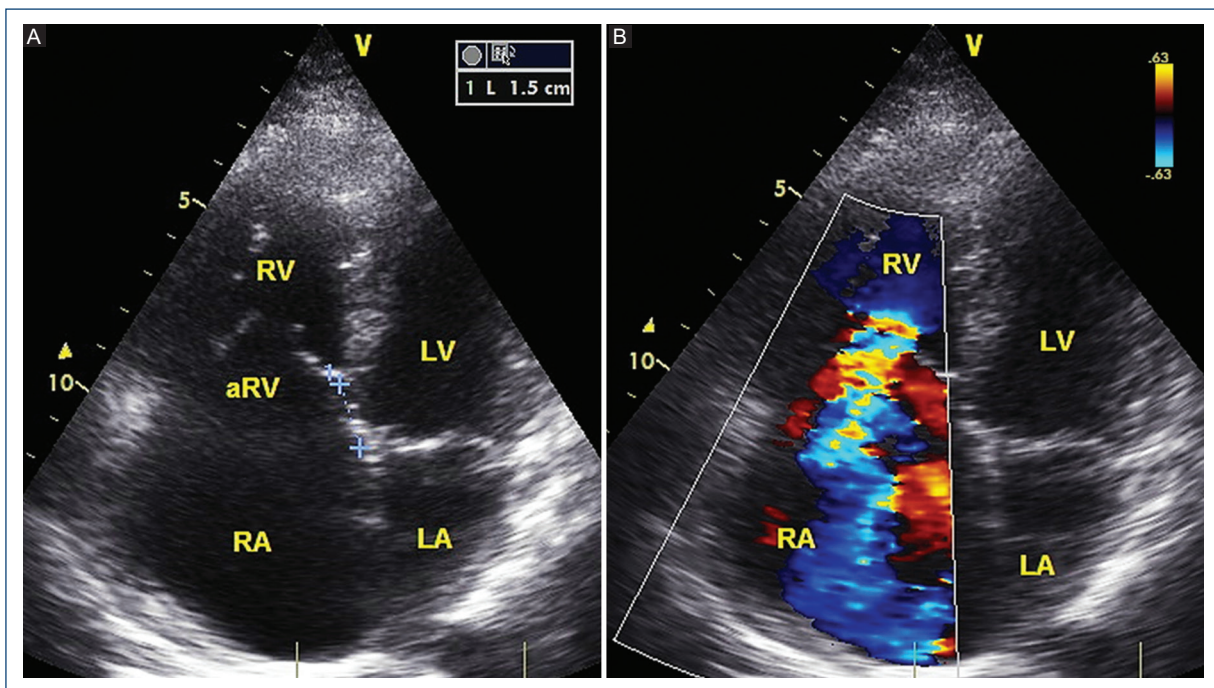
A: apical 4 chamber view which shows tricuspid septal leaflet attachment. B: apical 4 chamber view with Doppler color which shows severe tricuspid regurgitation. RV: right ventricle, aRV: atrialized right ventricle, RA: right atrium, LV: left ventricle, LA: left atrium).
